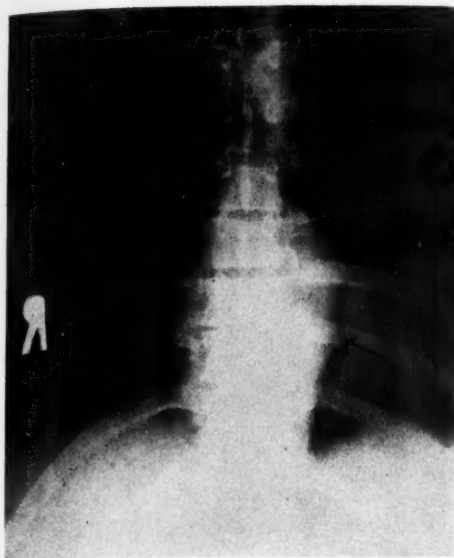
Antero-posterior roentgenogram of the spine in Case 3. The large very irregular abscess shadow is seen extending down to the diaphragm on the left. Slight decalcification of the bodies of the ninth and tenth thoracic vertebrae, together with narrowing of their intervertebral disc, is shown.
